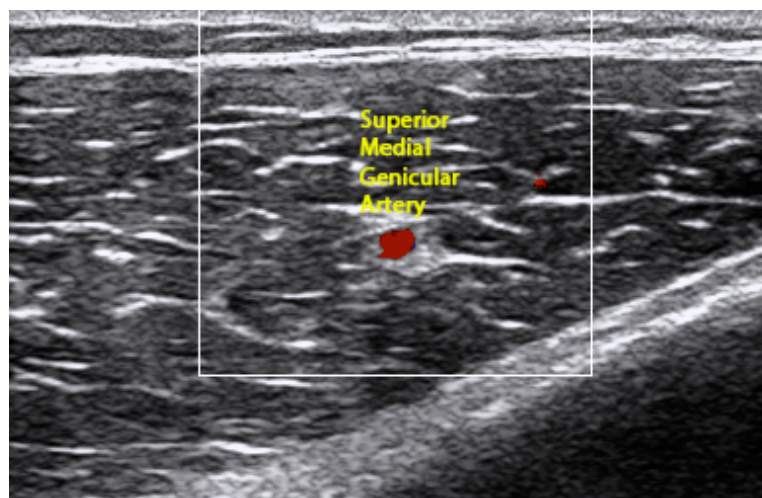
Color Doppler image demonstrating the superior medial genicular artery which serves as a landmark for the superior medial genicular nerve.
